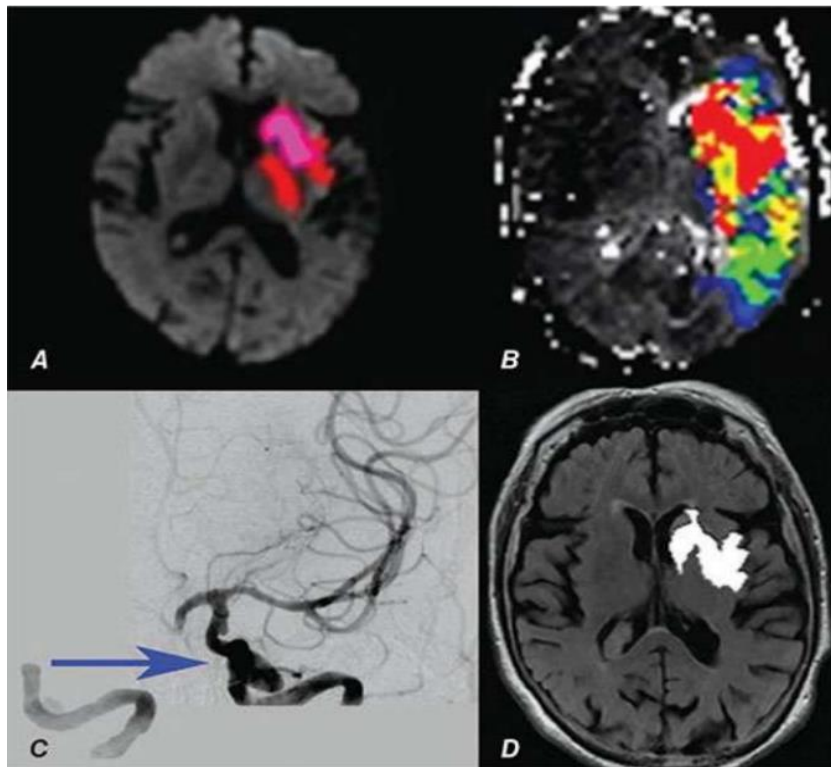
Magnetic resonance imaging(MRI) (17)
